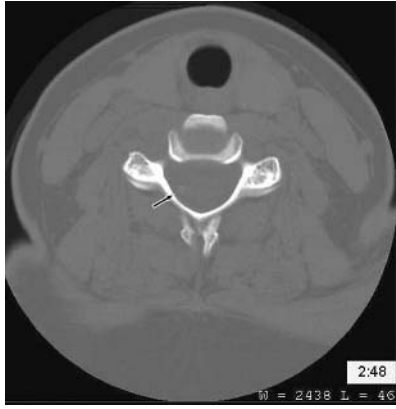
Computed tomography showing a tube (arrow) used for decompression of syrinx in the cervical cord.
